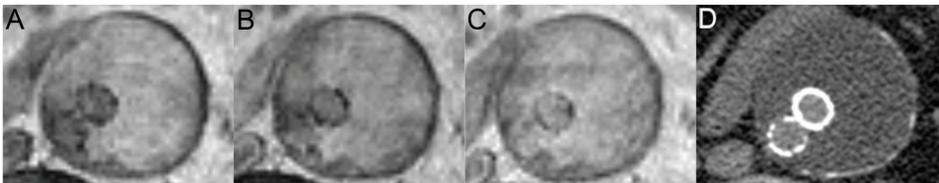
Patient no. 5 in Table 1. Stable aneurysm, 2 years after EVAR. Transverse precontrast(A), early postcontrast(B), late postcontrast(C) T1-weighted spin echo image (TR/TE580 ms/15ms) and delayed CT(D) at the same location. The aneurysm sac has high signal intensity on the MR images before contrast injection. No areas were identified with higher signal intensity on the postcontrast images, which is why the images were classified as 'no endoleak', also image subtraction did not reveal endoleak. Also in (D) no endoleak is visible.
